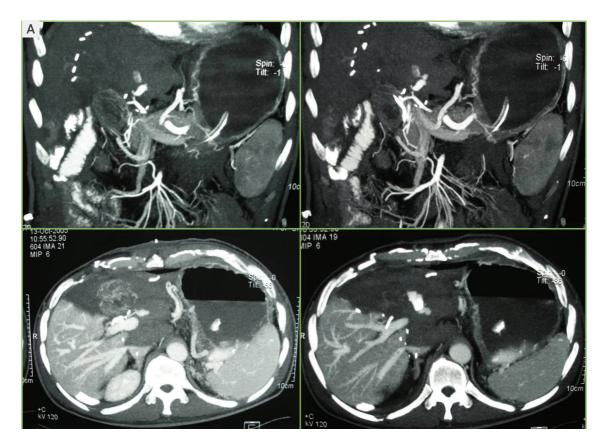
Fifty-Year-Old Patient on Day 2 After Right Lobe Transplant(A) Coronal and axial computed tomography images show acute bleeding of the hepatic artery from the side branch.
